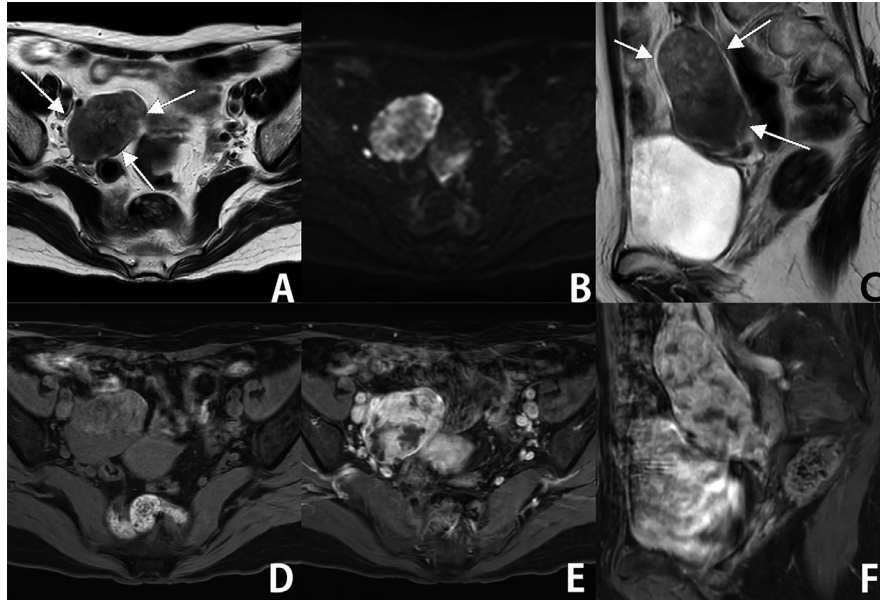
(A) Axial T2-weighted magnetic resonance imaging (MRI) showed a slightly hypointense mass located on the right side of the pelvis with a high signal on diffusion-weighted imaging (DWI) (B). (C) Sagittal T2-weighted MRI revealed an oval tumor with a clear boundary with the surrounding tissues. (D) Axial T1-weighted MRI with fat suppression demonstrating the tumor in hypointensity with artifacts on the ventral side originating from the peristalsis of the bowels. (E and F) MRI before and after administration of contrast material. On contrast-enhanced axial and sagittal MRI, the tumor was heterogeneously enhanced with patchy hypo-signal areas.
